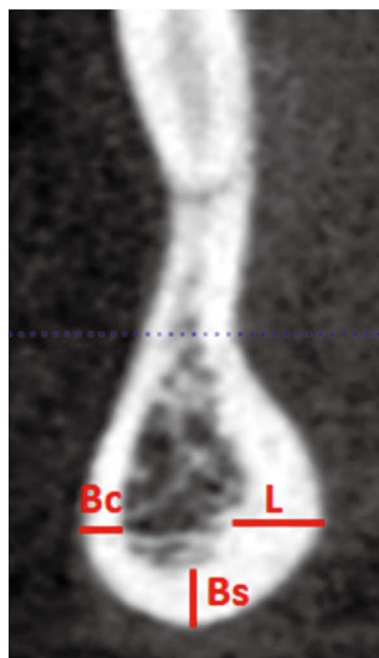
The cortical bone thickness in the buccal (Bc), lingual (L), and basal (Bs) aspects is measured on a parasagittal section of cone-beam computed tomography.
